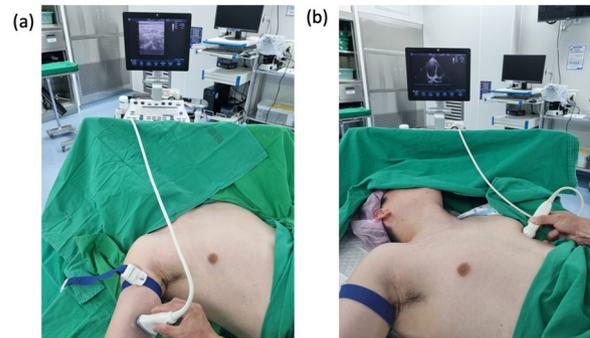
(abstract 000260) . Before antiseptic draping, (a) rapid assessment of peripheral vein by linear probe* (b) mark the best point which echocardiography by apical 4-chamber view or subcostal view shows clear right cardiac cavity by cardiac probe*
